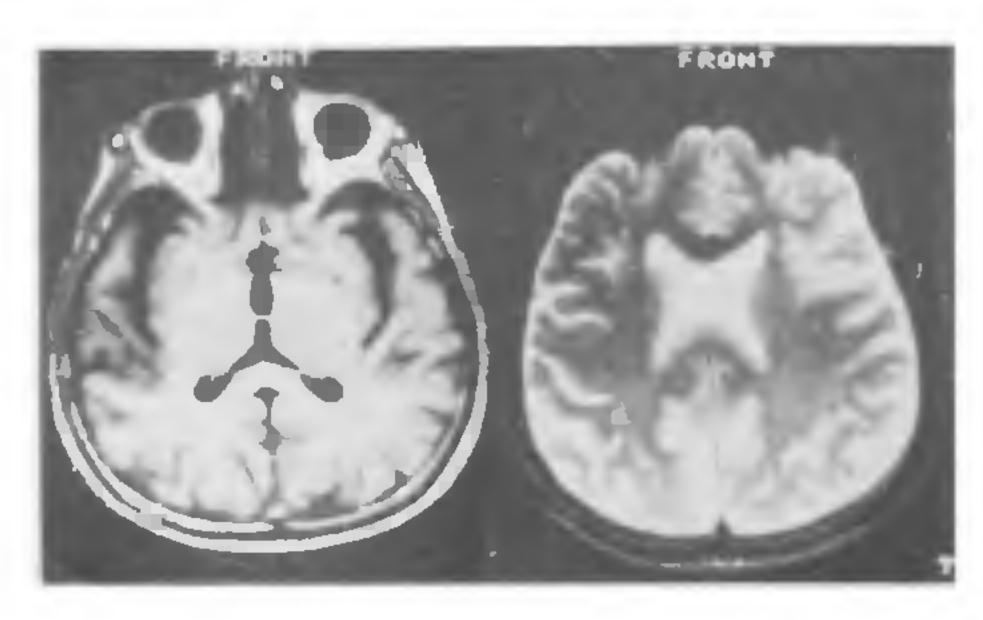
T₁W₁ axial brain MRI revealing marked dilatation of Sylvian cistern and cerebral cortical sulci of a patient with Alzheimer's disease (on the left). Another section (T₂W) shows marked cortical alrophy without much ventricular dilatation. No cerebral infarcts are seen (on the right).
